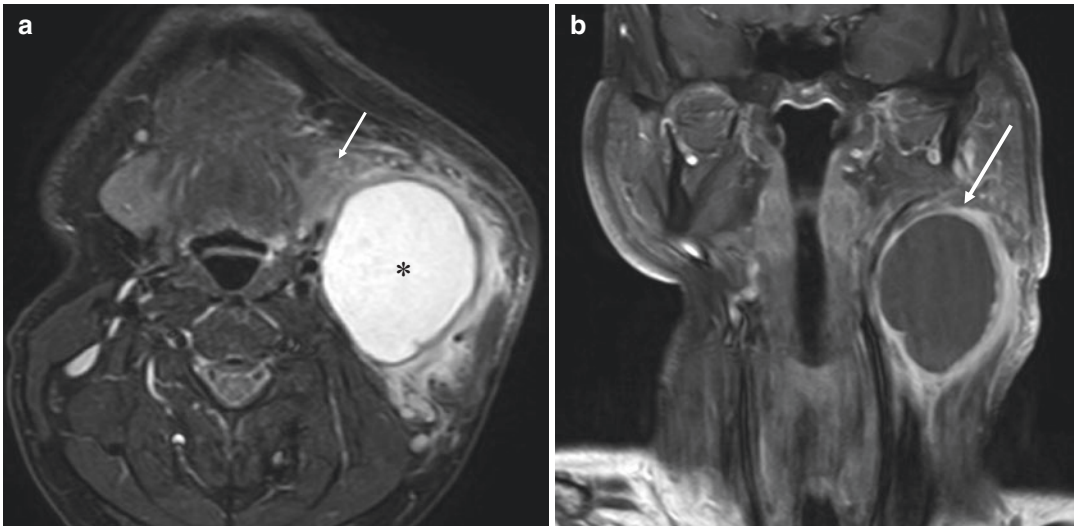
(a) Axial fat saturated T2 weighted MRI revealing a smooth thin-walled cyst (asterisk) in the left upper cervical region (level IIA) with surrounding fat stranding. The left submandibular gland is displaced anteriorly
